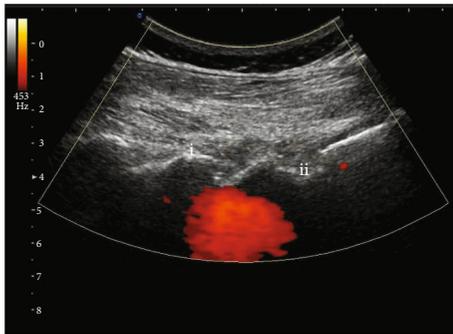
Ultrasound-guided transforaminal injection in out-of-plane approach. Ultrasound-guided transforaminal injection was performed, and the needle tip was positioned in the middle of (i) L5/S1 facet joint and (ii) sacral foramina. The red signal represented the spreading of drug in targeted epidural space.
